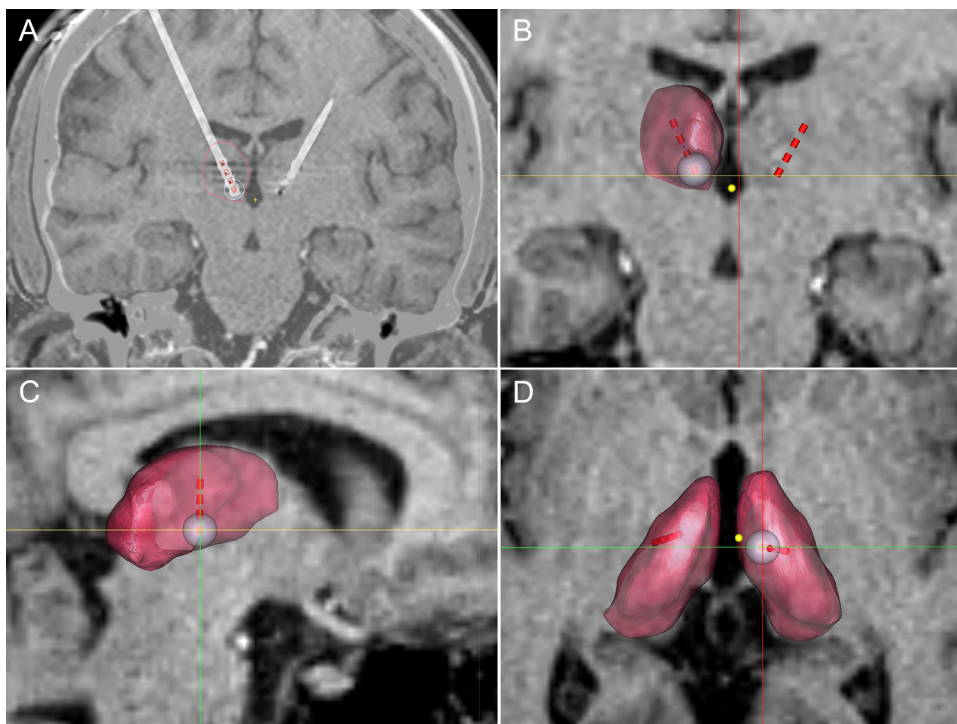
Fusion images of pre-surgical MRI and post-surgical CT. A–D Fusion images show parafascicular thalamic nucleus bilateral DBS targeting using leads model 3387 (Medtronic Minneapolis, USA). (A) The figure shows the quadripolar right lead, it is easy to identify the four contacts 8, 9, 10, and 11, separated from each other 1.5 mm. (B) Coronal view of the parafascicular right thalamic nucleus, first contact (8) is being stimulated at 2.5 V, 90 μ s and 130 Hz. The circle represents the power field of that stimulation on dark red the right thalamus. (C,D) sagittal and axial 3-D view of the right thalamus and the position of the lead and stimulation of the most inferior contact (8).
